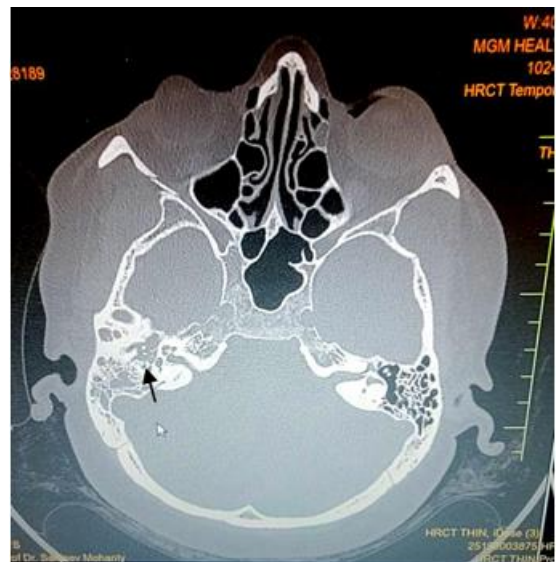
(a) High resolution computed tomography image showing soft tissue density in the right middle ear cavity - axial cut
